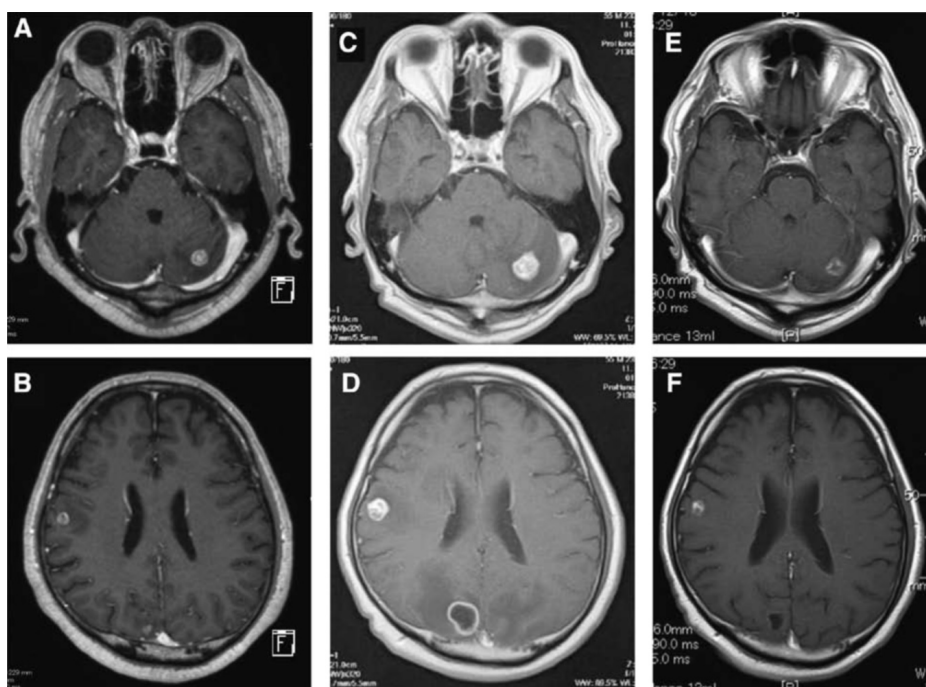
Magnetic resonance imaging of the brain (A,B) before and (C,D) after whole brain irradiation, (E,F) after two cycles of chemotherapy of bevacizumab, paclitaxel, and carboplatin.
